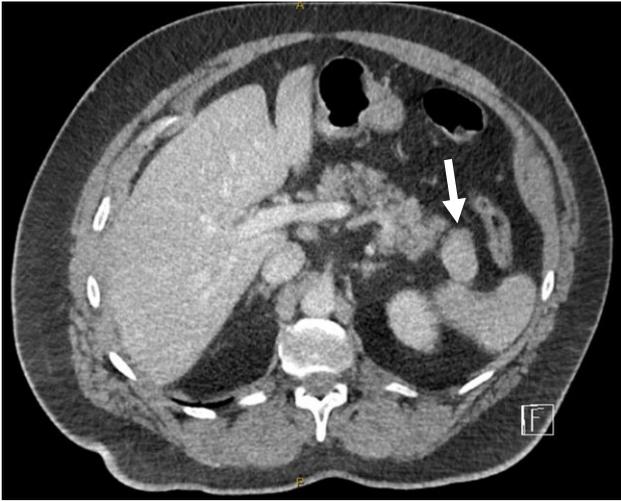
Axial contrast-enhanced CT pancreatic protocol images demonstrating a well-defined, homogeneous lesion within the pancreatic tail (arrow). The lesion exhibits enhancement patterns identical to the adjacent splenic parenchyma across arterial and portal venous phases, a characteristic feature of intrapancreatic accessory spleen.
